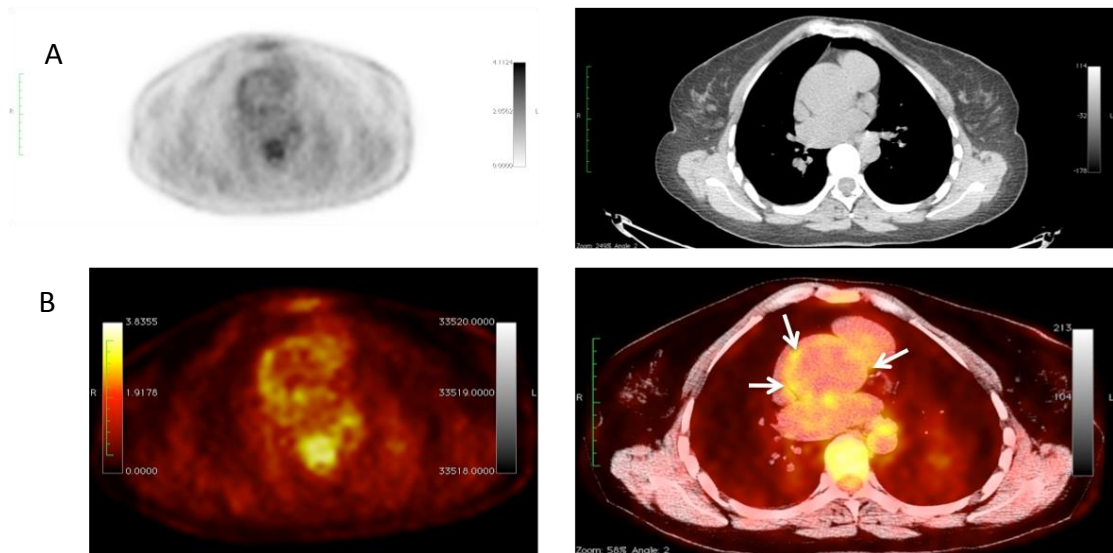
Fused aortic PET-CT
